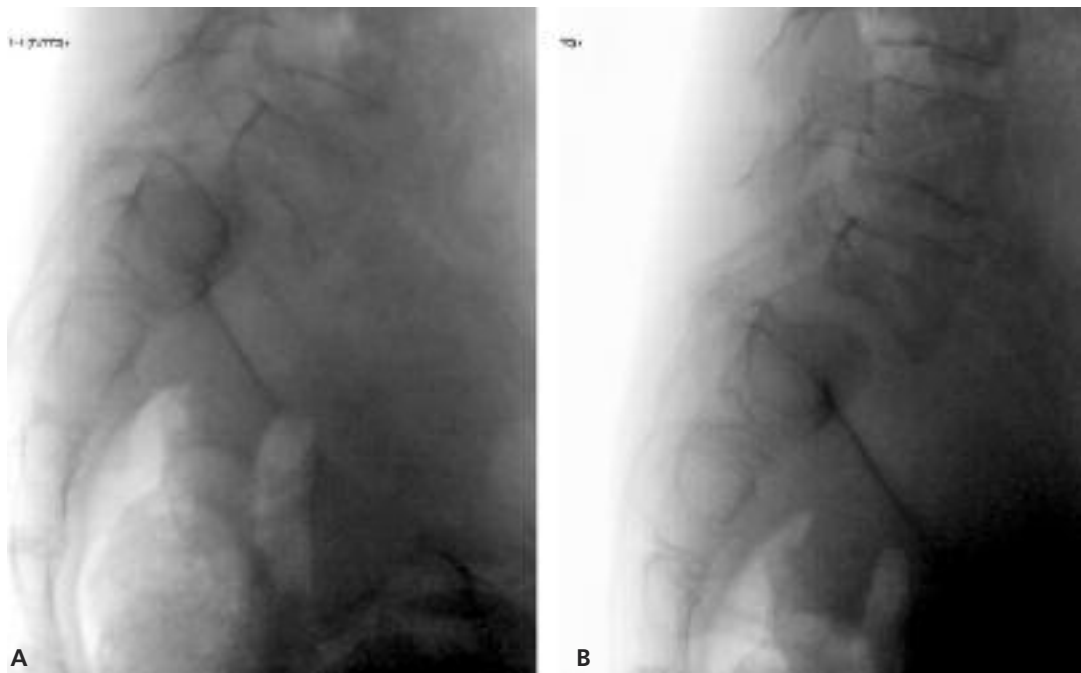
Preoperative dynamic X-ray. *(A)* During the flexion the spondylolisthesis worsens to grade III. *(B)* During the extension L5 aligns the sacral plate reducing the spondylolisthesis at grade I. This exam confirms the vertebral instability.
